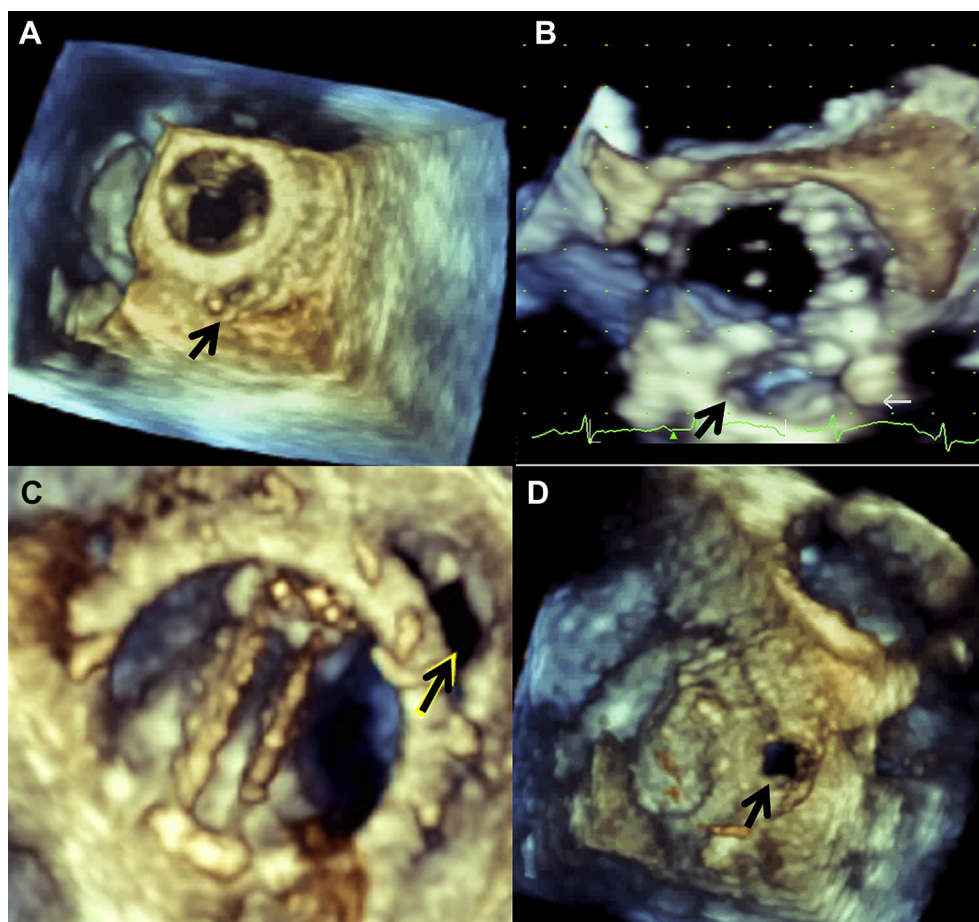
Three dimensional echocardiography demonstrating various shapes of leaks. A small circular leak in 5 o' clock posterior position of mitral annulus of a bioprosthesis on atrial enface view (A), a large oval leak in anterior aortic annulus of a single disc mechanical prosthesis on aortic enface view (B), a crescentic large leak on the bileaflet mechanical mitral prosthesis in 2 o' clock position on atrial enface view (C) and a large square shaped leak on another bileaflet mechanical mitral prosthesis in 2 o' clock position on atrial enface view (D) are demonstrated.
